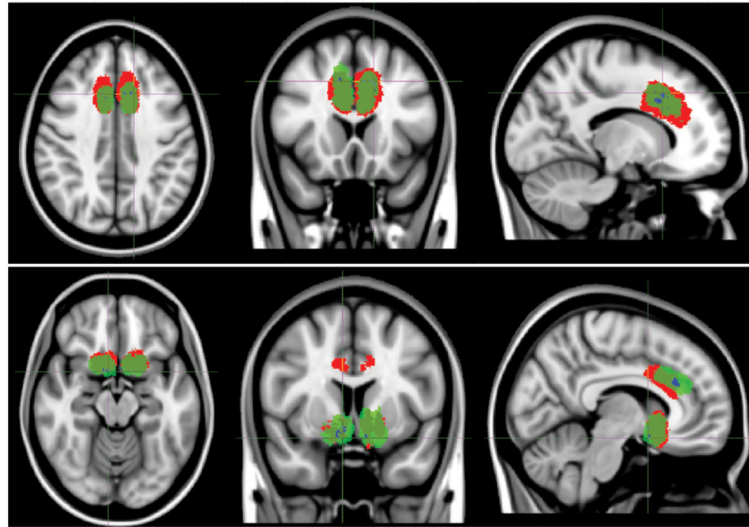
Lesion volumetry. Three-dimensional projection of representative anterior cingulotomy (*yellow*) and limbic leucotomy (*blue*), displayed on coronal and sagittal T1-weighted MNI152 templates (*left to right*).
